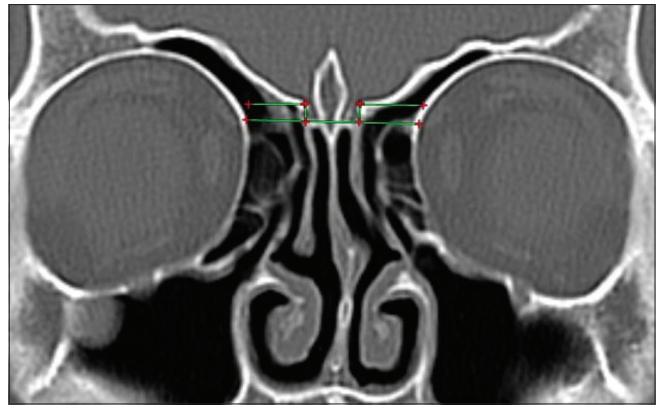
Coronal CT demonstrating type I Keros classification. Olfactory fossae are not very deep. Ethmoid roofs are almost in the same plane as the cribriform plate
